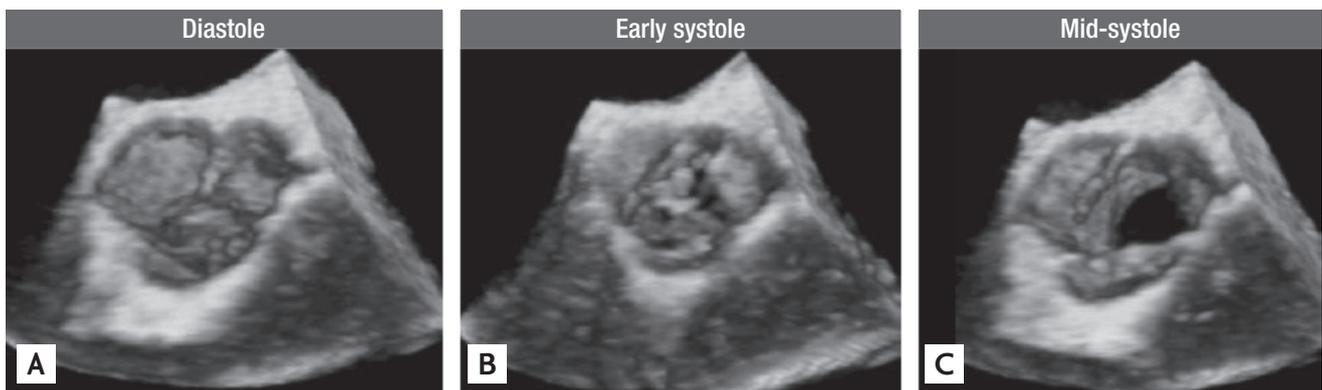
Three-dimensional transesophageal echocardiography images of normal aortic valve in a cardiac cycle (A, diastole; B, early systole; C, mid-systole).
